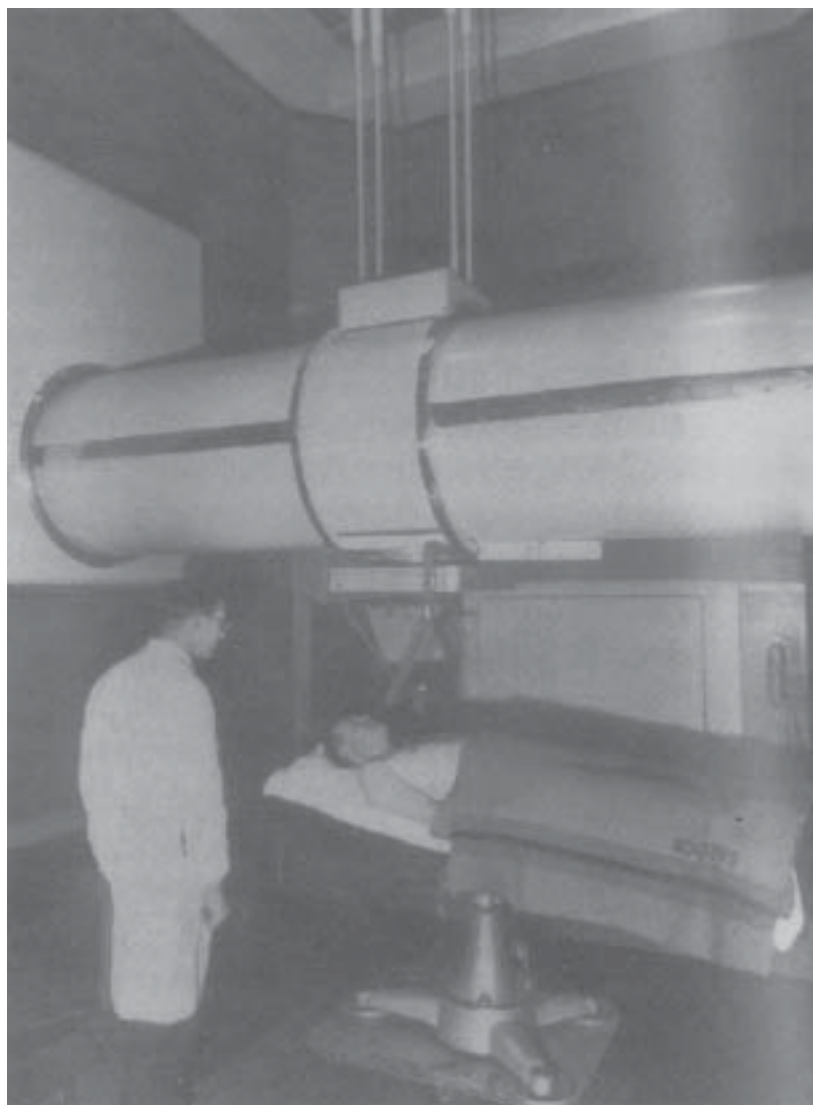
Dr. Ralph Phillips and a patient to be treated using the 1-million-electron-volt (MeV) therapy installation at St. Bartholomew's Hospital, London. The unit created high-energy, penetrating X rays that could be used for treating cancers and other tumors. The immediate benefit to the patient of the eradication or reduction of the tumor generally was thought to outweigh the risk of developing future cancers from the high radiation dose delivered by such a therapy device. Source: Laughlin JS. Radiation therapy. *RadioGraphics*. 1989;9(6):1252. Photograph: Reprinted with permission from *Brit J Radiology*. British Institute of Radiology, London, England.
